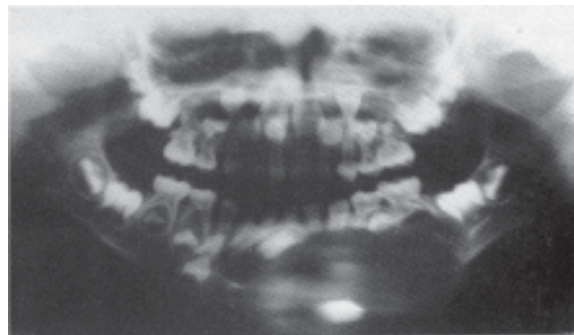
An orthopantomogram demonstrating a cyst occupying almost the whole height of the mandible.
